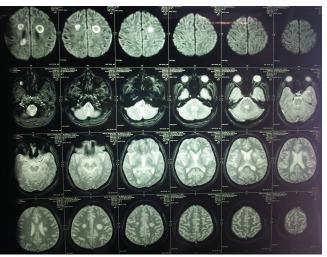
MRI reveals characteristics concentric halos
